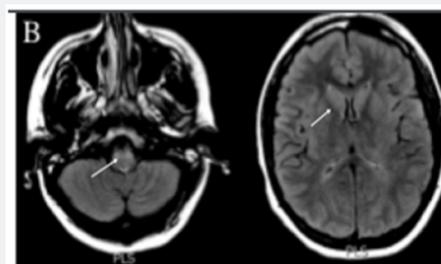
Day 3 MRI showing T2 hyperintensity in the medulla/pons and edema in the basal ganglia.
